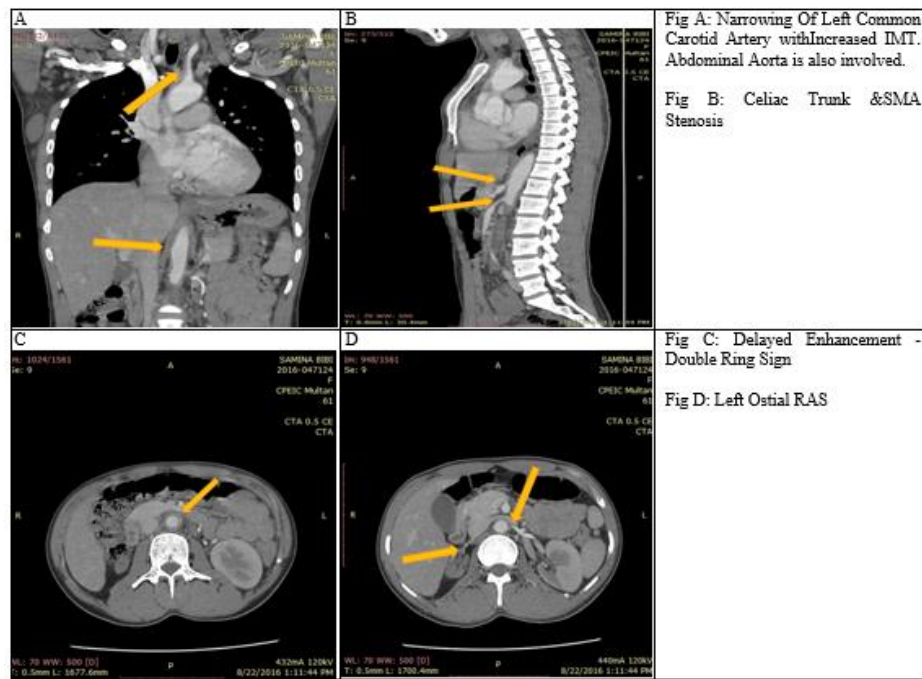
CTA Pictorial Findings of Patient C
